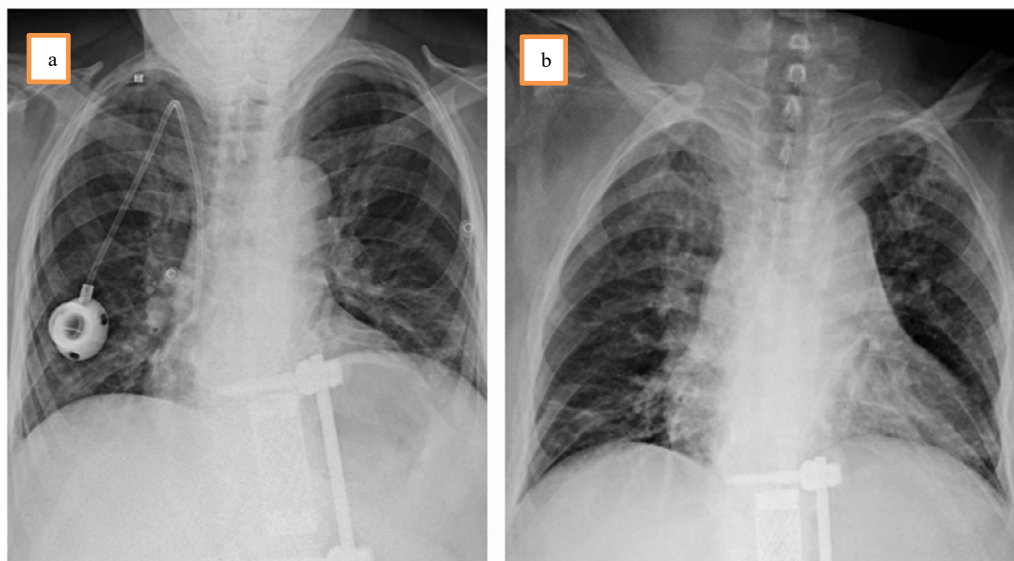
Chest radiograph showing (a) port catheter fracture/kinking and (b) successful percutaneous retrieval
